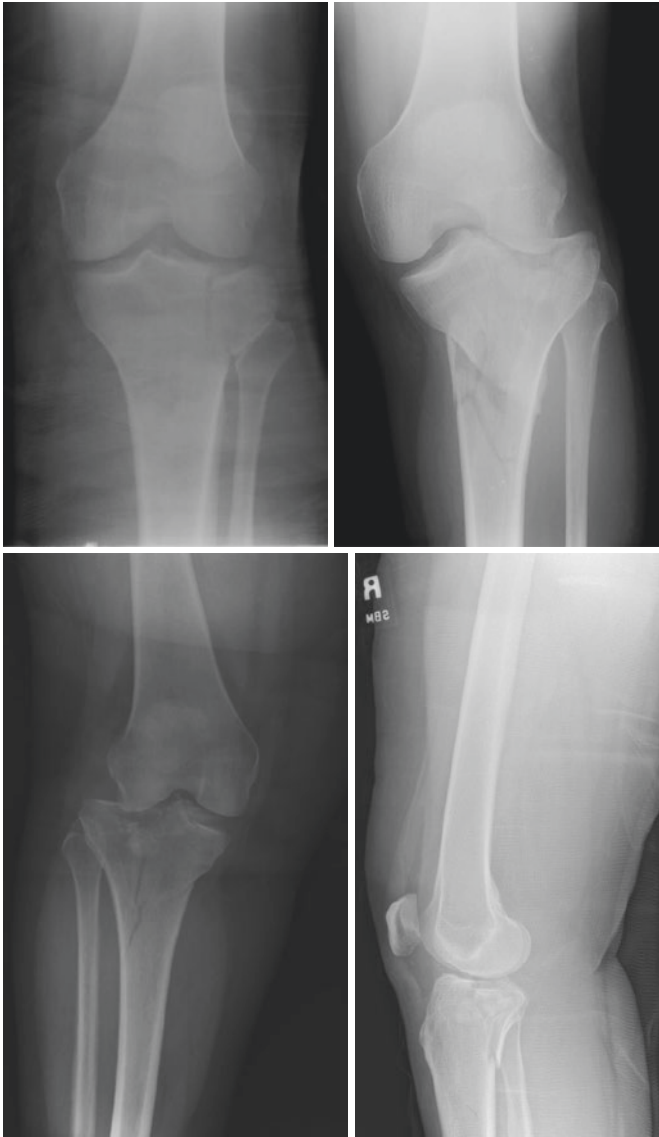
Representative AP and lateral radiographic images of tibial plateau fractures
